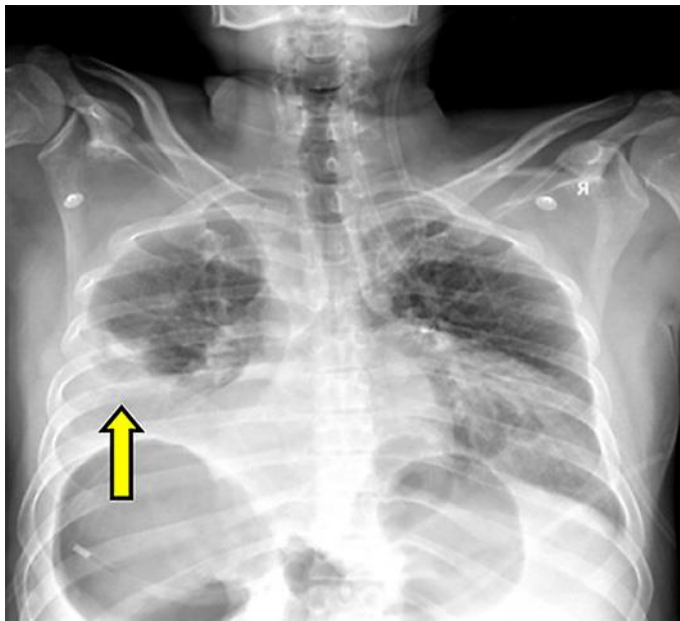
Chest X-ray reveals a raised right hemidiaphragm with a homogeneous opacity at the right lower lobe with obliteration of the right costophrenic angle.
